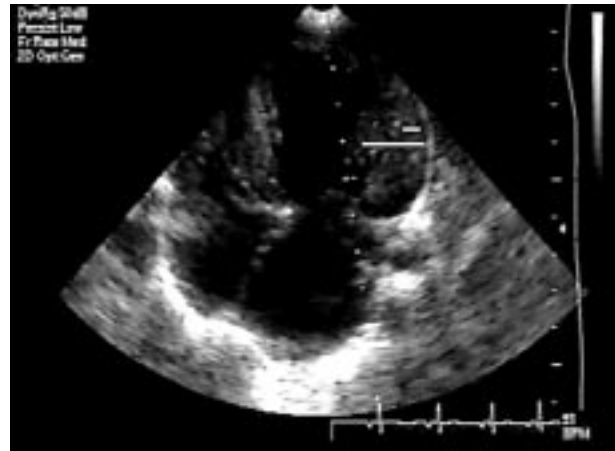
Two-dimensional echocardiogram, four-chamber apical view. Significant left ventricular hypertrophy. Two sections of myocardium can be clearly seen in the left ventricular free wall. One is compacted (short white line), while the other is non-compacted with trabeculae that create deep recesses (long white line). The ratio between the thickness of the compacted and the noncompacted myocardium is <0.5 .
